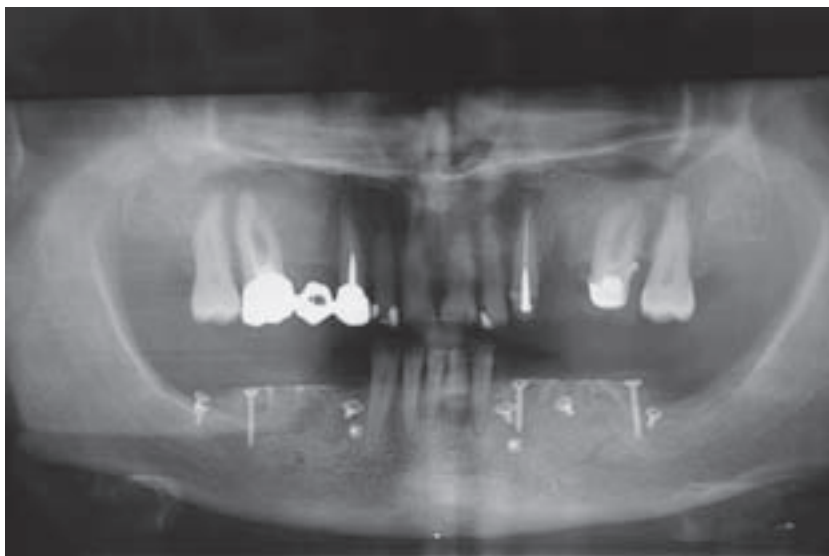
Orthopantomogram after bilateral guided bone regeneration with e-PTFE membranes.
